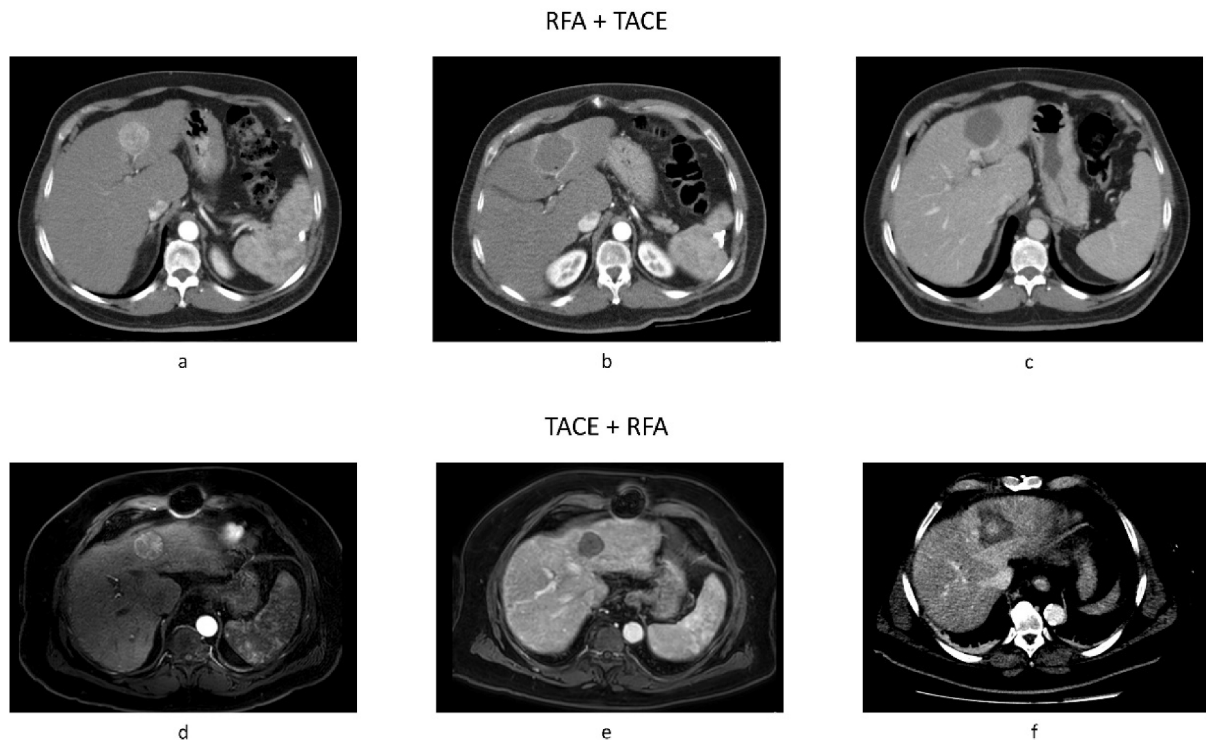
Two cases of patients treated with different treatment sequences. Adjuvant TACE was used in the first case (A: diagnostic CT, B: post-ablation CT, C: post TACE CT) Neo-adjuvant TACE was used in the second case (D: pre-treatment gadolinium-enhanced MRI in arterial phase, E: pre-treatment gadolinium-enhanced MRI in portal venous phase, F: post-treatment CT scan).
